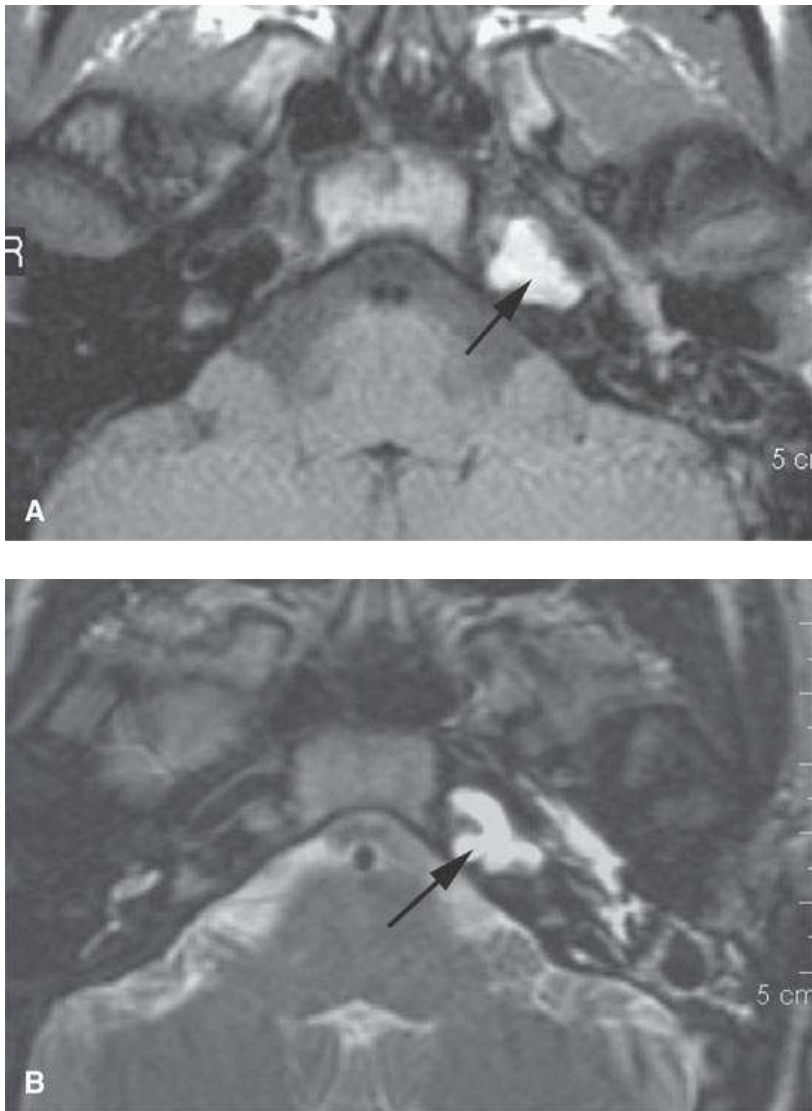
Magnetic resonance imaging of a patient with surgically proven cholesterosis (cholesterol granuloma) of the petrous apex. A: T1-weighted non–contrast-enhanced image shows the bright signal (*arrow*) petrous apex due to cholesterol in solution and/or chronic blood products. B: T2-weighted image is nonspecific, showing only that this is likely some sort of fluid collection (*arrow*) or possibly an epidermoid cyst since low signal of chronic blood products could not be confirmed.
